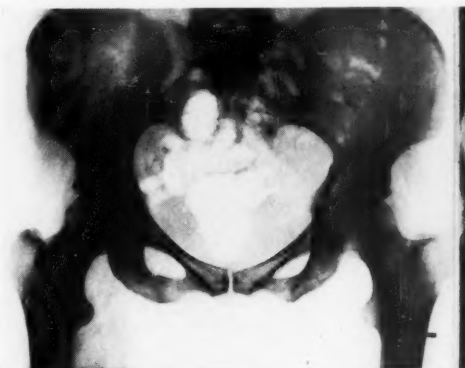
Case 3: Roentgenogram of pelvis, showing commencement of carcinomatous invasion.
